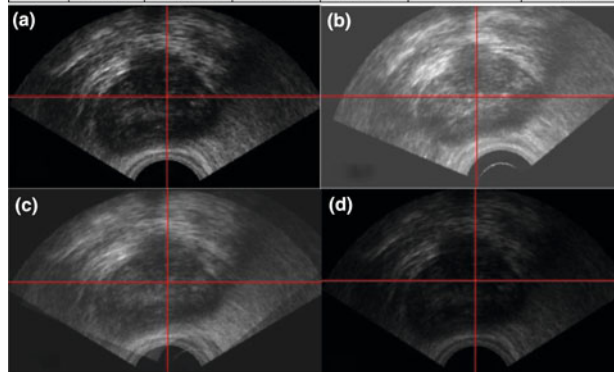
The table above is the result of ultrasonic to ultrasonic registration. Hie NVI is short for Hierarchical NVI. w_1 and w_2 mean average displacement before and after registration. p_1 and p_2 mean average displacement in rotation before and after registration. Run_Time is the average run time for registration and Sample_Rate gives the sampling rate. The images below are one slice of 3D ultrasonic image in our surgical navigation system. (a) The reference image; (b) The test image after random transform; (c) Overlapping of the reference image and the test image; (d) Overlapping of the reference image and the transformed test image after registration using Hierarchical NVI
